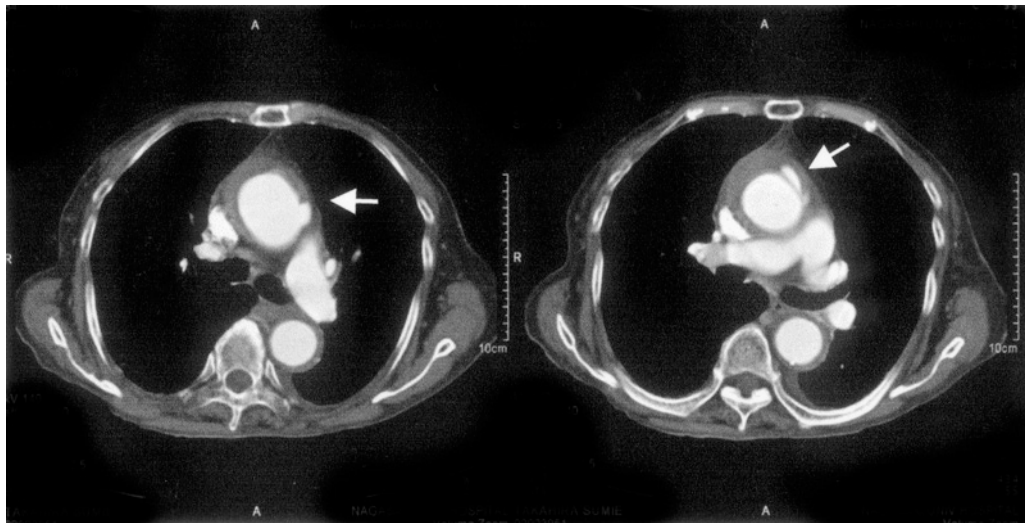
A contrast-enhanced computed tomography on November 21, 2003. Ascending aorta was dilated (about 6 cm in diameter). Thrombus in the pseudolumen was increased, and pseudolumen was dilated especially in the ascending aorta compared to the previous CT (Fig. 3). Ulcer-like projection was seen in the thrombosed pseudolumen of the ascending aorta (arrows). Left pleural effusion was seen.
